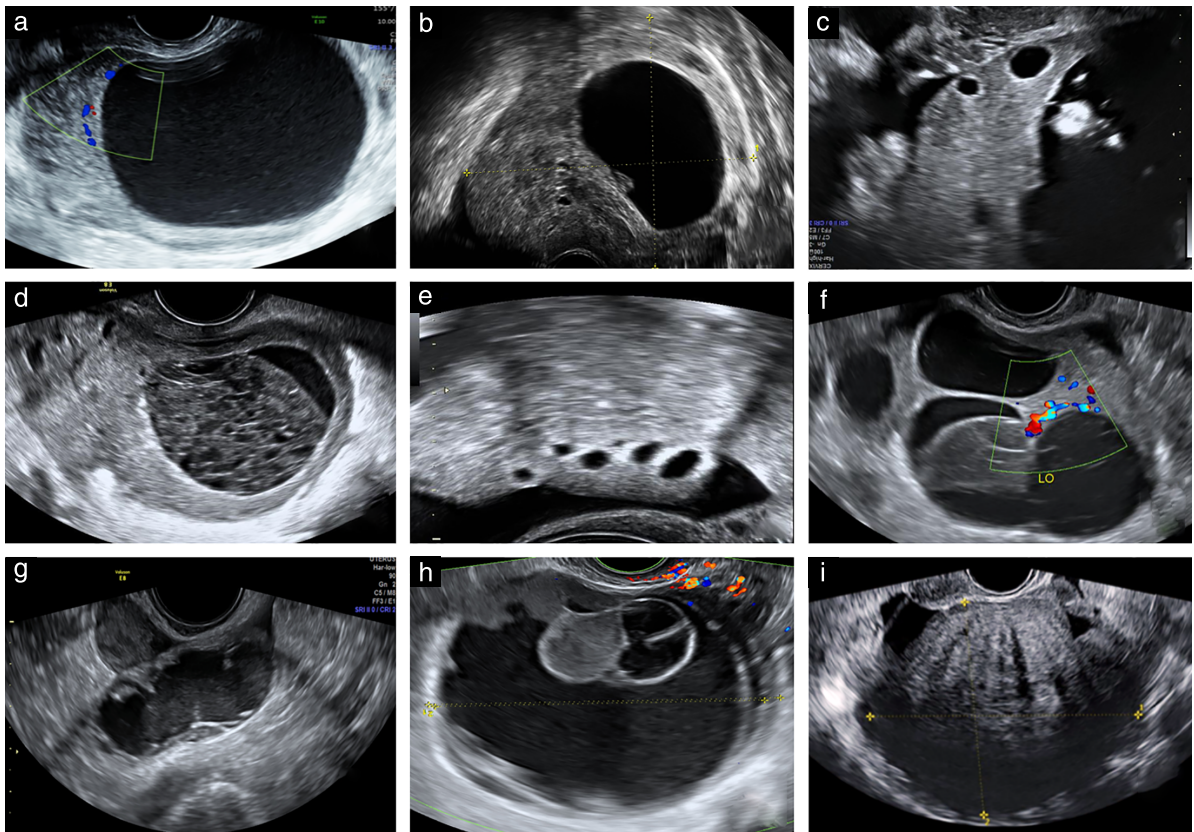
Ultrasound images of twisted ovaries with adnexal masses: (a,b,f) serous cystadenomas; (c,e) mature cystic teratoma; (d) corpus luteum; (g) Fallopian tube with pyosalpinx; (h) mucinous borderline tumor; and (i) fibroma. Ovarian stromal edema with or without peripherally displaced antral follicles is seen in (a–f) and follicular ring sign is seen in (c–e).
